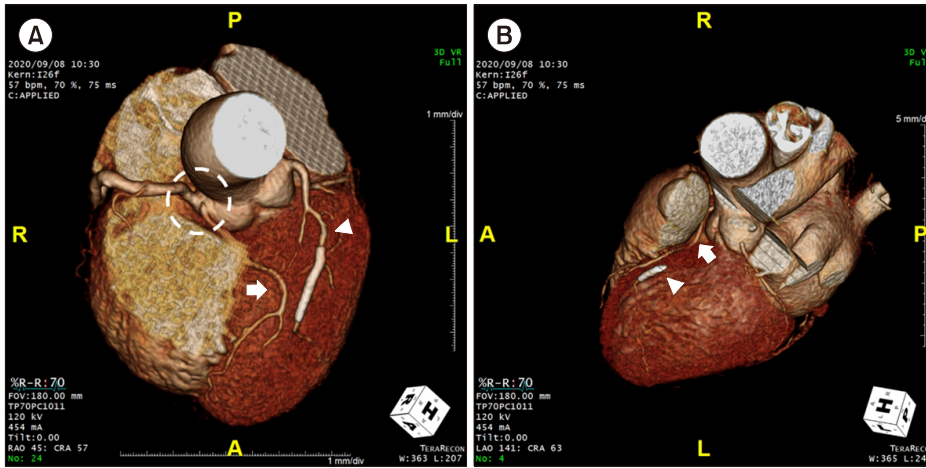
Three-dimensional coronary computed tomography angiography image demonstrates anomalous dual left anterior descending artery (LAD) with a long LAD originating from the right coronary sinus independently from the right coronary artery, coursing between the right ventricular outflow tract and the aortic route, and continuing as mid- to distal LAD (arrow) and the stented big diagonal branch of the short LAD (arrowhead).
